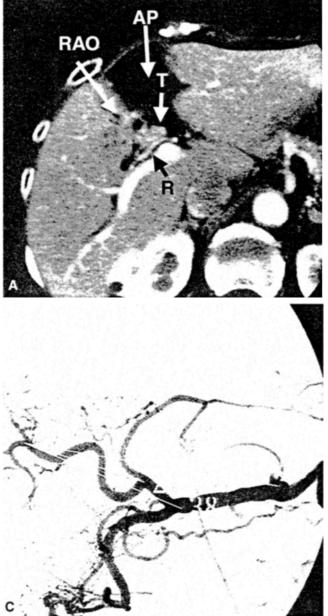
A 78-year-old woman with hilar bile duct carcinoma. A Contrast-enhanced CT shows the right hepatic artery (R) running behind the tumor of the bile duct (T) from the left anterior side to the right posterior side. AP and RAO indicate the projected angle on anteroposterior and right anterior oblique images of arteriography. The RAO projection is more orthogonal to the running course of the right hepatic artery than is the AP projection. AP projection (B) and RAO projection (C) celiac arteriography. Numbers indicate the length of each line (mm). The lengths between the bifurcation of the anterior and posterior branch of the liver and the bifurcation of the left and right hepatic artery and the gastroduodenal artery are longer on C than on B.
